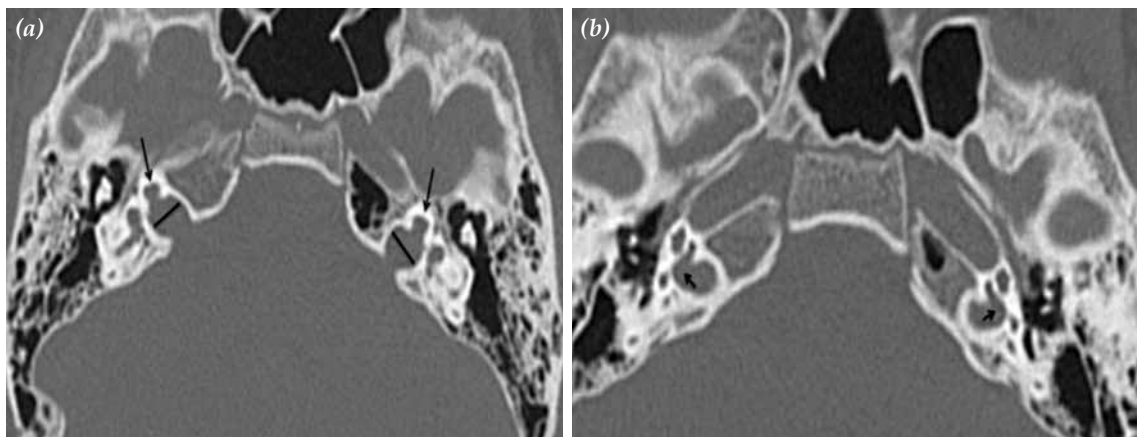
High resolution computed tomography, axial sections, showing bilateral bulbous dilatation at the lateral ends of both internal auditory canals. The basal turns of the cochlea were incompletely separated from, and seemed to be a continuation of the internal auditory canals (arrows).
